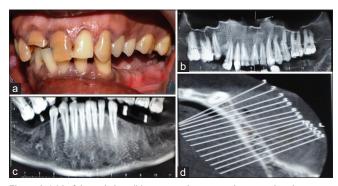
(a) Left lateral view, (b) computed tomography scan showing upper arch, (c) computed tomography scan showing lower arch, (d) computed tomography scan showing the narrow alveolar bone width of the lower-right arch
